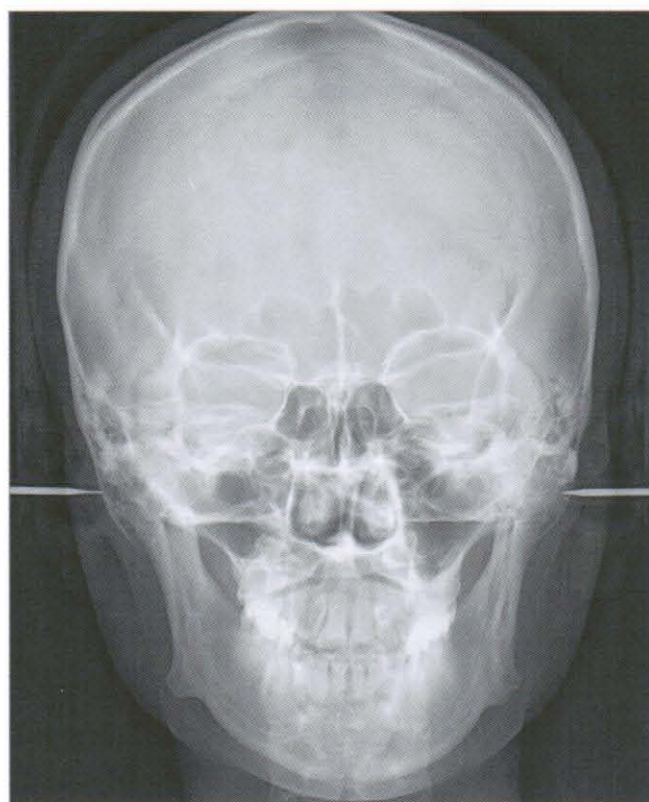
Postero-anterior radiograph at 1 year retention (2008, 3,21)
